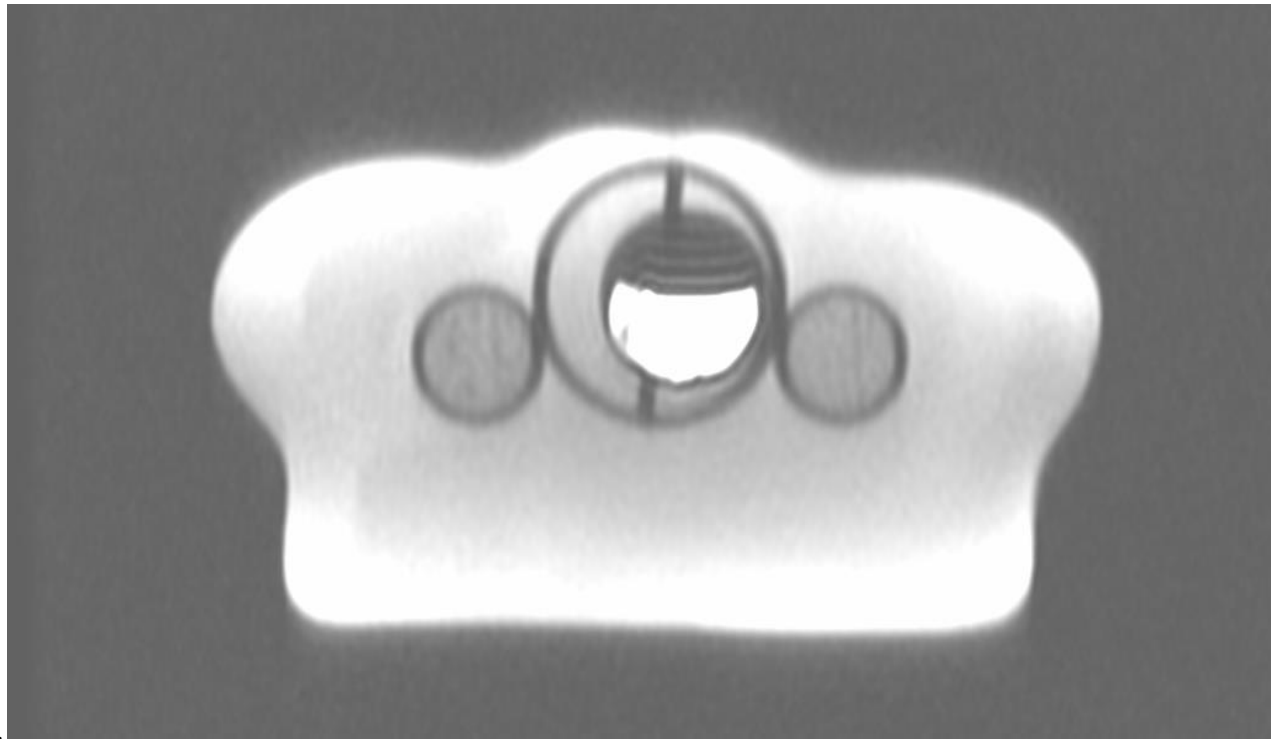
Prostate ROI highly enhancing on T2-weighted MRI in axial plane.
